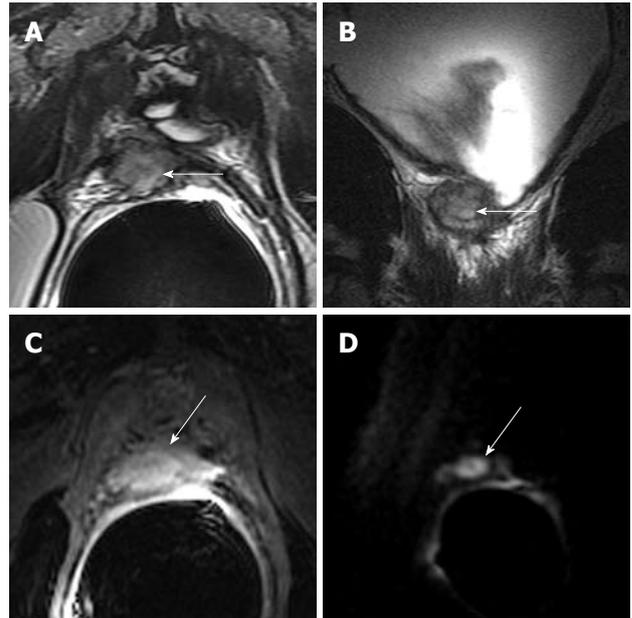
1.5T MR images of locally recurrent prostate cancer in a 63-year-old man with rising PSA levels after radical prostatectomy. Transverse 3 mm-thick T2-WI (4000/125) (A) and coronal 3 mm-thick T2-WI (5300/100) (B) show intermediate SI mass (arrows) to the right posterior aspect of the bladder neck at the anastomosis; C: Transverse 3 mm-thick T1-WI (5.5/2.4) shows significant enhancement of the mass (arrow) after intravenous administration of gadolinium; D: Transverse 3 mm-thick diffusion-weighted image (DWI) (3500/93, b-value of 1000 s/mm²) shows intense increased signal (restricted diffusion) throughout the mass (arrow).
